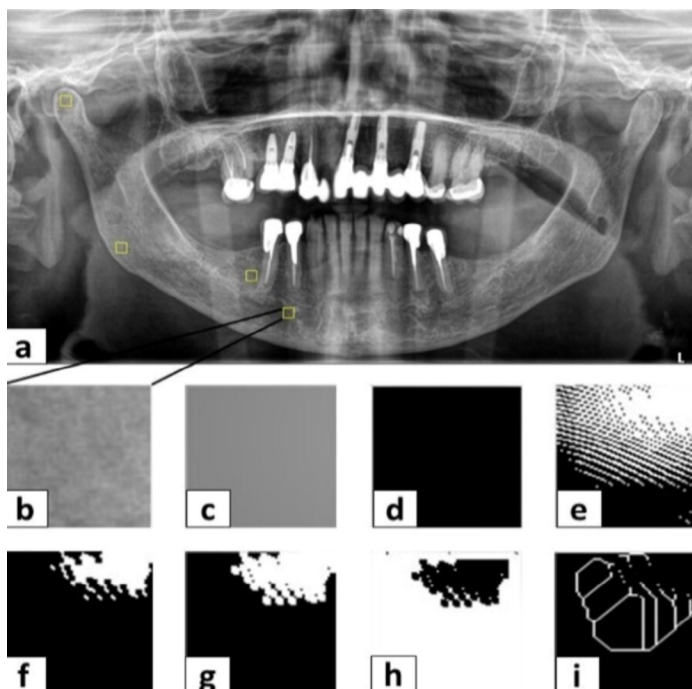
Panoramic radiograph showing a fractal dimension in a selected region of interest. a) Panoramic radiograph. b) Selected ROI. c) Blurred image with Gaussian filter. d) Subtraction of region of interest from the original image. e) Addition of 128 gray value to each pixel location. f) Binarization. g) Erosion. h) Dilatation. i) Skeletonization.
